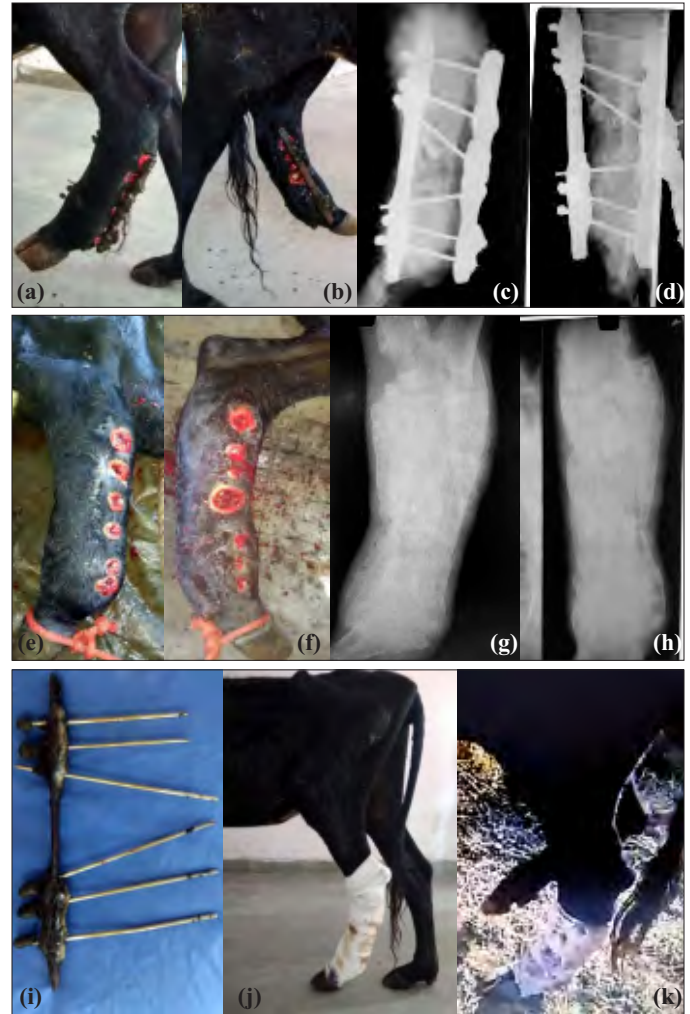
Post-operative observations after 16 months; MT bone with ESF (a) lateral and (b) medial view; radiographs with fixator (c) lateral and D/planter view; after removal of fixator (e) lateral and (f) medial view; radiographs (g) lateral and (h) D/planter view; (i) removed fixator, (j) weight bearing on the day of removal of fixator; (k) full weight bearing while walking, 7 days after removal of fixator (Entire weight is borne on the affected limb while the normal limb is in air).
